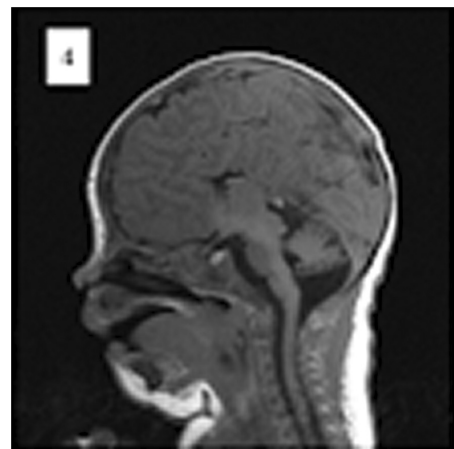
Brain MRI images: Brain MRI without contrast, sagittal T1/performed at the first week of life. Figure 3 and this figure show corpus callosal agenesis, and cerebellar hypoplasia.
